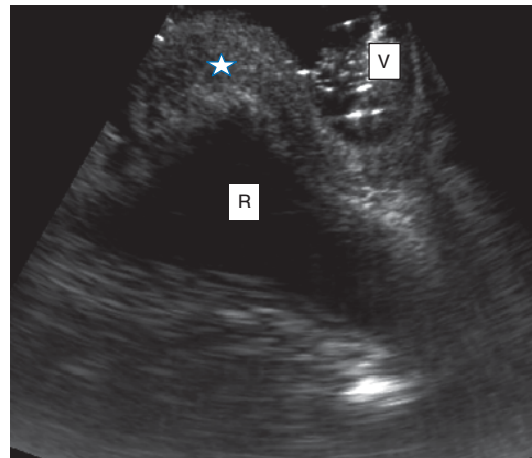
Sagittal transperineal ultrasound showing locoregional recurrence in the rectogenital septum (star). The vagina is filled with contrast (V) and the rectum is air-filled (R).
